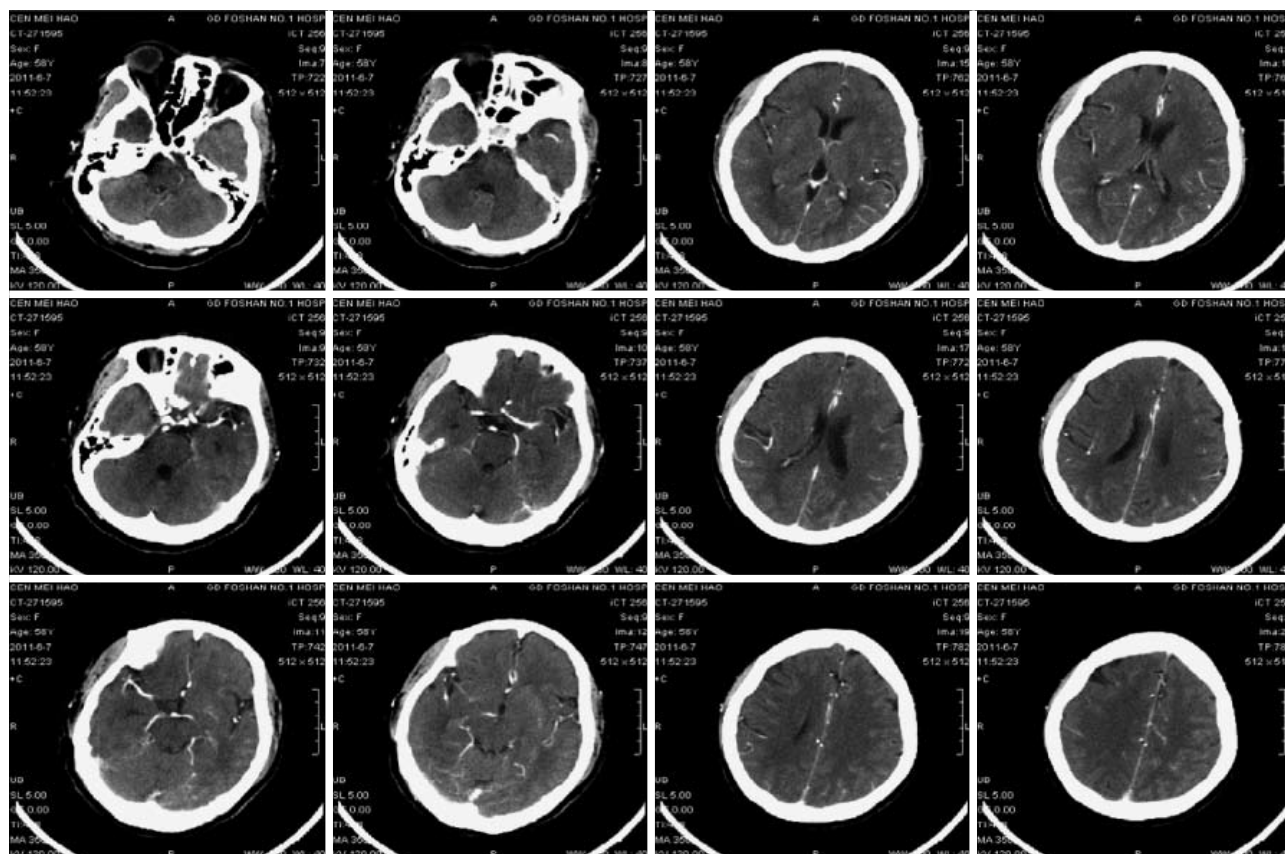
Enhanced computed tomography and magnetic resonance venography scan of the brain of case 2. Mild cerebral arteriosclerosis, stenosis of the A1 segment of the right anterior cerebral artery and right intracranial artery, and effective blood supply of distal vascular and mild lacunar infarction of bilateral basal ganglia.
